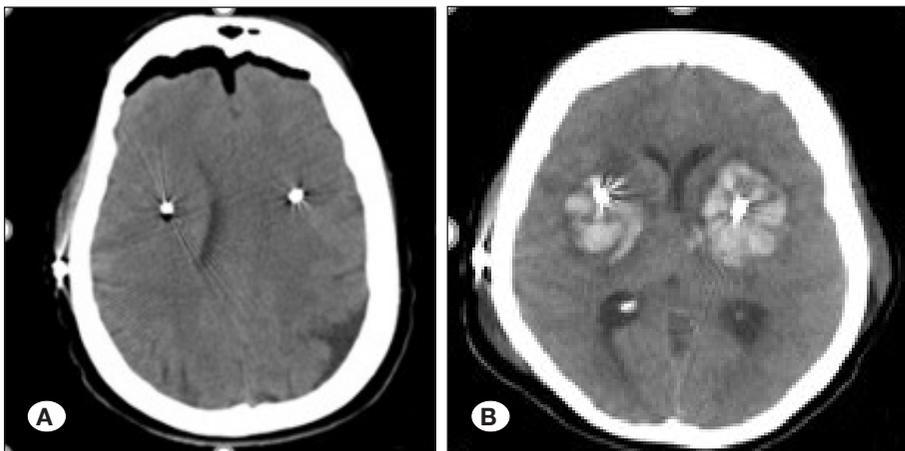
A) Axial CT scan slice showing no bleeding. B) Two days after surgery, an axial CT scan slices showing bilateral hemorrhage around the electrode.
